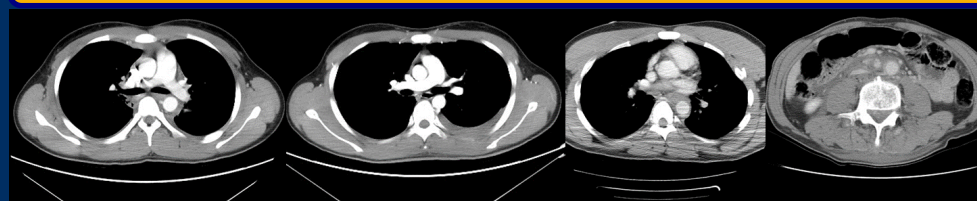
CT image of periaortic hematoma in the 4 patients
